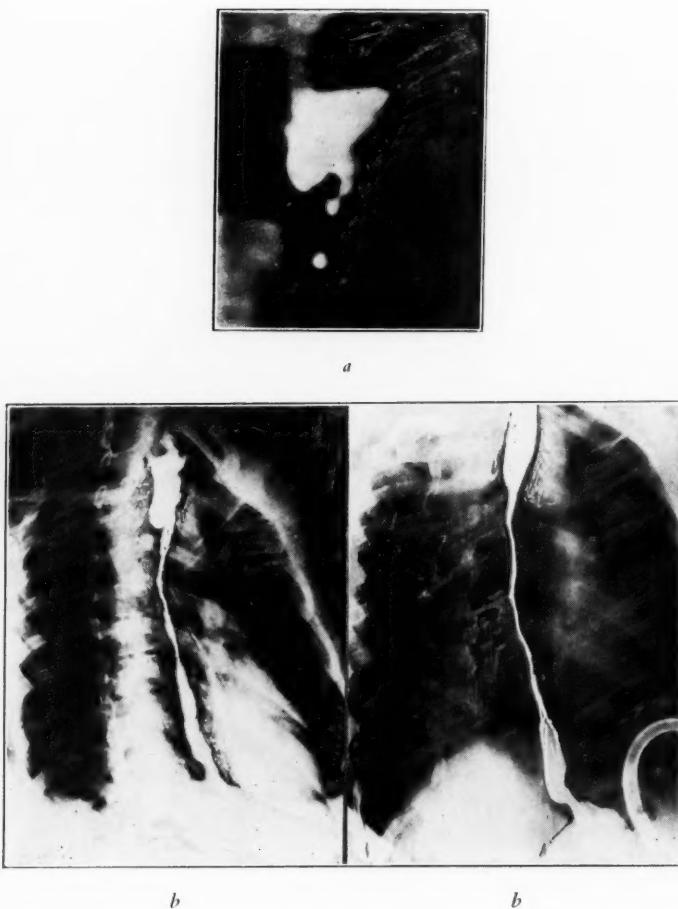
X-ray films (retouched) of a boy of sixteen, who swallowed caustic five months previously.
